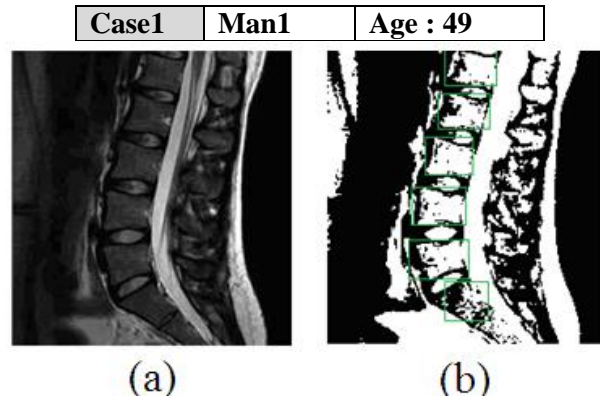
Discs Lumbar Selection. (a) Origin MRI , (b) Six Disc selection.
